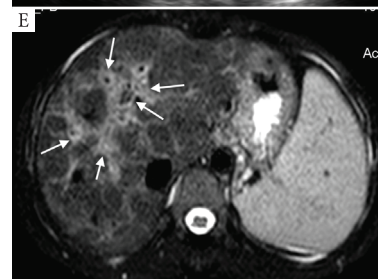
Transverse T2-weighted MR scan of the liver showing periportal oedema (arrows).
